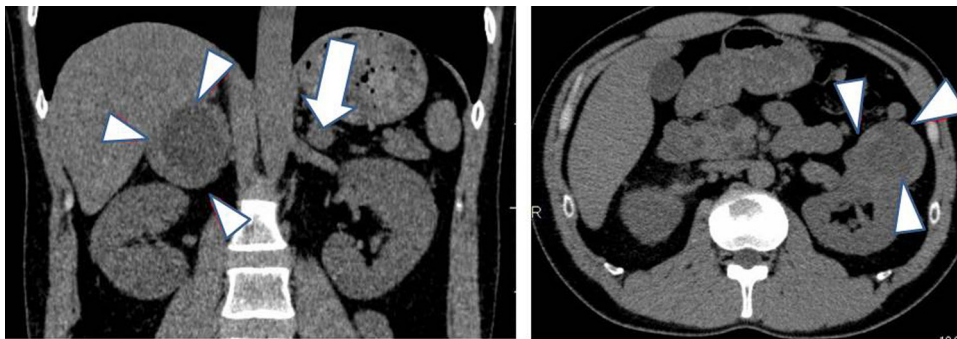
Abdominal CT scan showing bilateral adrenal tumors (the right and left masses were 5.5 and 1.5 cm in diameter, respectively).
